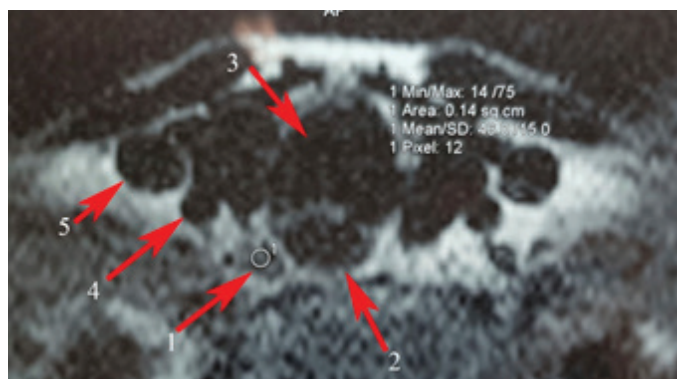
MRI-image. MRI of the neck with intravenous contrast. Arrows indicate anatomical structures: 1 - the right upper parathyroid gland; 2 - the esophagus; 3 - trachea; 4- right common carotid artery
